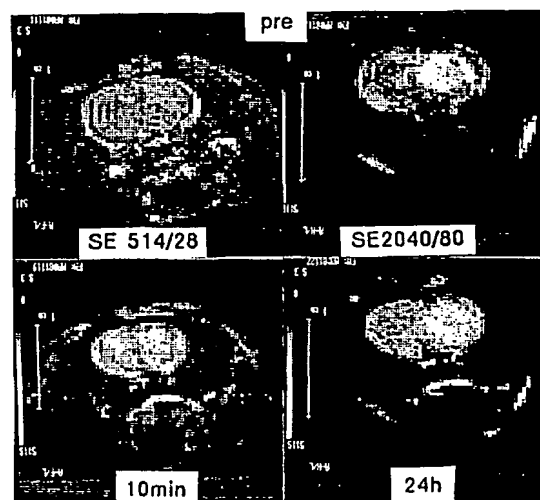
MRI showing the 9L tumor. Upper row showing pre-contrast T1 image (left) and T2 image (right). After injection of Gd-MoAb, the tumor is enhanced after 10 min, and also after 24 hours
